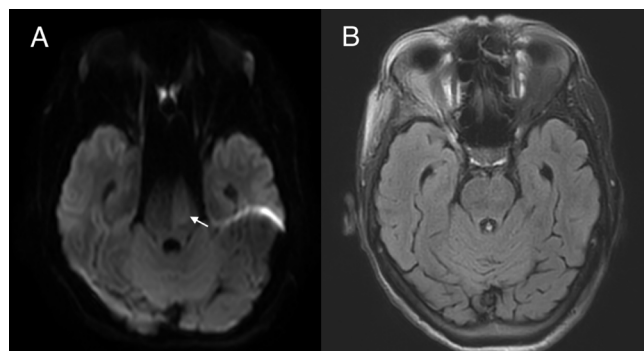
A – Axial DWI image (b=1000) showing a left hemipontine acute infarct (white arrow). B – Axial FLAIR image at the same level shows no abnormal high signal intensity (FLAIR-negative).
